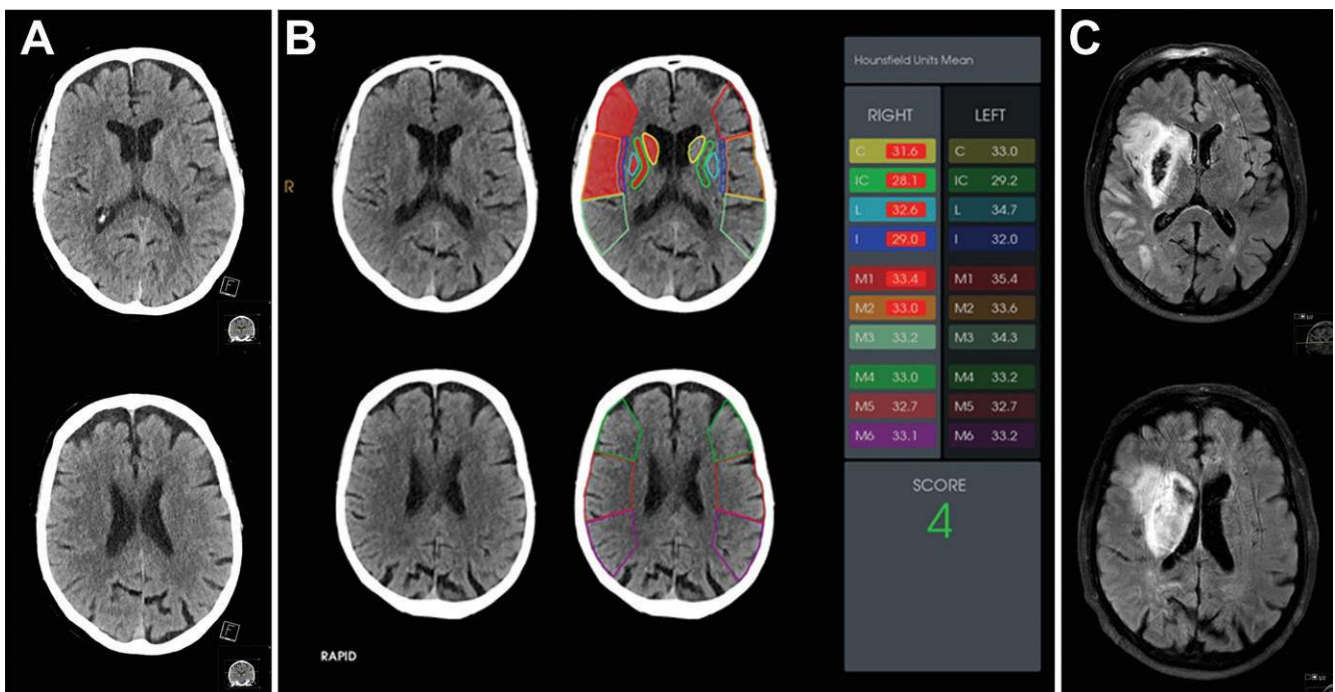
A, B, Axial CT images and, C, axial fluid-attenuated inversion recovery MR images in a 74-year-old woman with right-sided stroke due to occlusion of M1 segment. Automated software showed much greater agreement with consensus score than with human readers. A, Two human readers each scored 8. B, Software analysis assigned Alberta Stroke Program Early CT score (ASPECTS) evaluation of 4. Consensus score ASPECT was 4. C, This patient was promptly treated with thrombectomy (grade 3 on Thrombolysis in Cerebral Infarction scale) and had fluid-attenuated inversion recovery-ASPECTS evaluation of 3 on third day after intervention.
